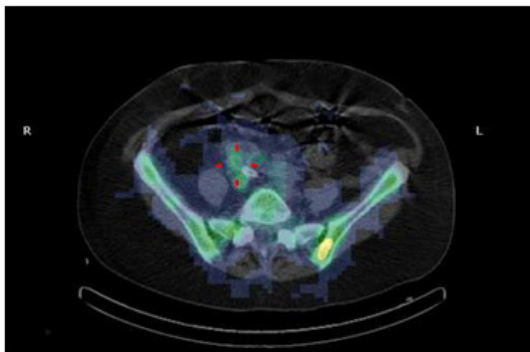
^{99m}Tc -HMPAO leukocytes gammagraphy with single photon emission computerized tomography (SPECT) showing the affected right graft limb of the aorto-bifemoral by-pass graft.
